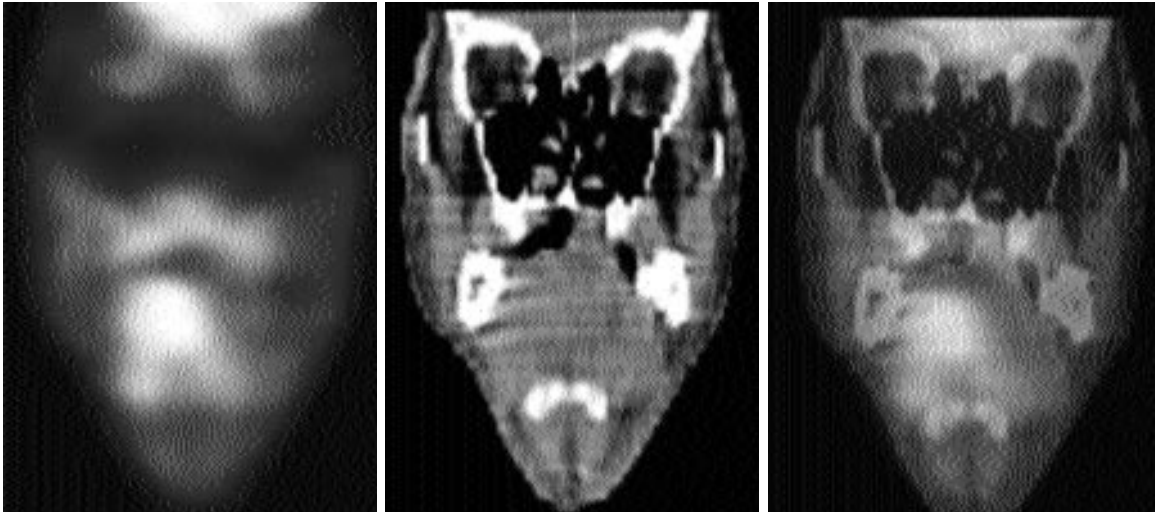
Recurrence of squamous cell cancer at the floor of the mouth. Uptake on PET asymmetric to CT. Differentiation is only possible by PET/CT.
